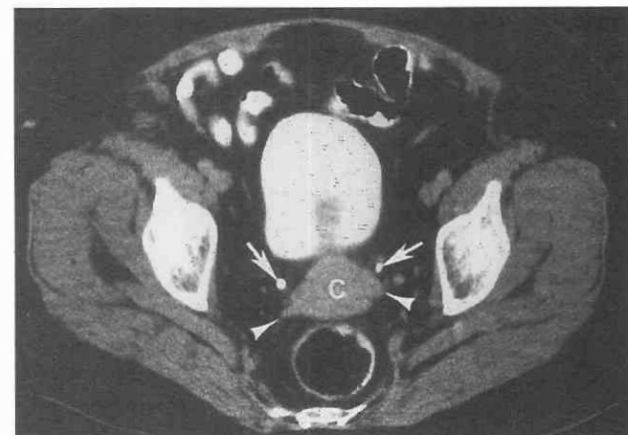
Normal anatomy. CT scan with delayed images through the cervix (*C*) shows triangular cardinal ligaments (*arrowheads*) tapering laterally and contrast-filled pelvic ureters (*arrows*) anteriorly.
